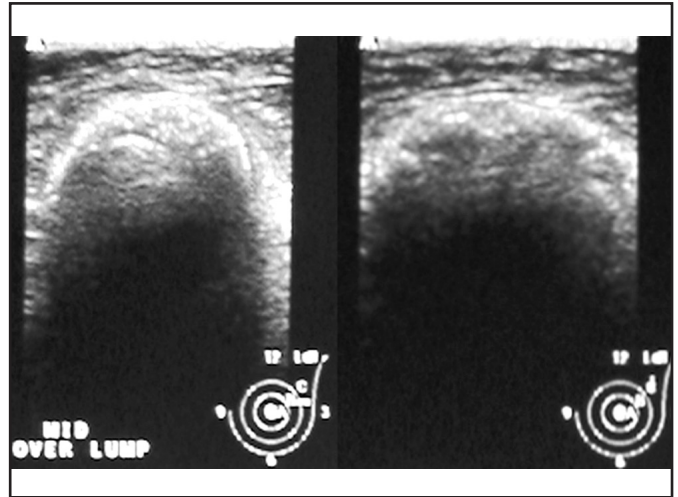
Transverse and oblique ultrasonographic images show a well-circumscribed, rounded lesion with prominent posterior acoustic shadowing. It is located in the axillary tail of the left breast.
